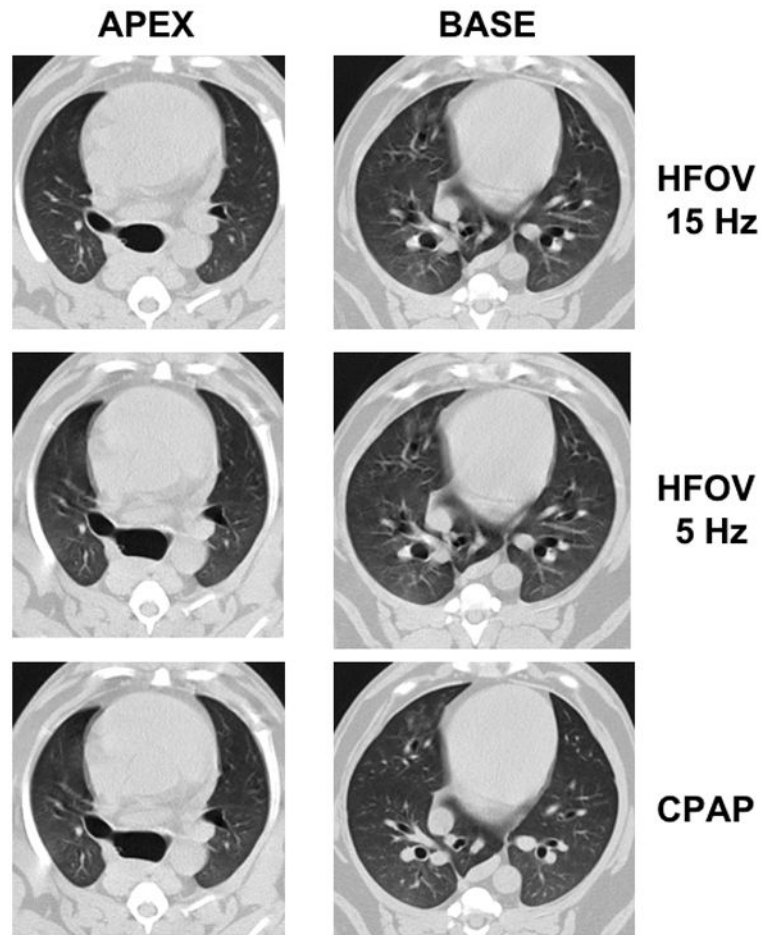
Representative CT images from a typical subject during HFOV and CPAP at P_{aw} 5 cmH_2O . Anatomically matched lowermost apex slice and uppermost base sub-volume slices are presented. Distinctive anatomic landmarks are easily identified between conditions. Note the lack of lung motion artifact even during HFOV at 5 Hz compared to the heart border.
